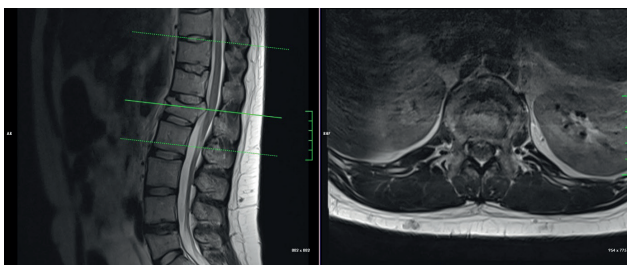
T2 weighted sagittal and axial MRI reveal loss of vertebra height due to burst fracture in L1 vertebra corpus and narrowing of spinal canal.
